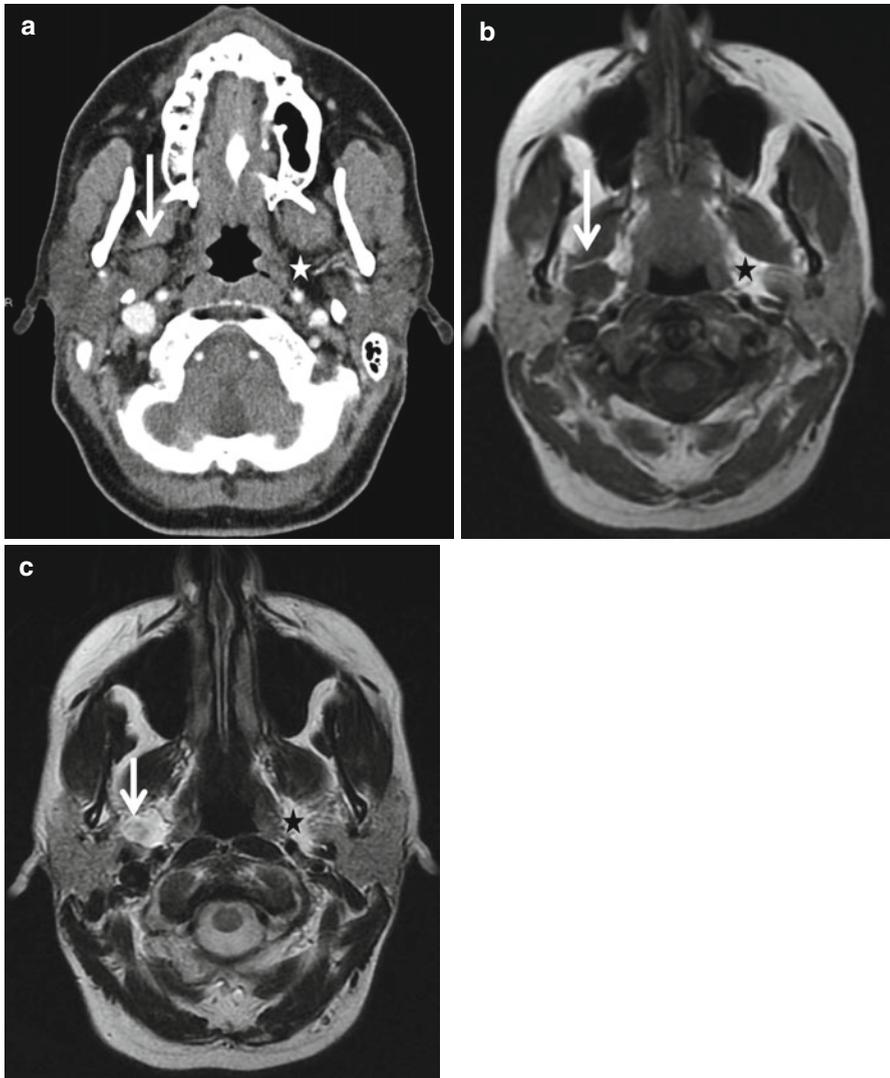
Pleomorphic adenoma. Axial CT (a) and T1- and T2-weighted MR images (b and c) display a well-circumscribed lesion centered within the right parapharyngeal space (*white arrow*). Note the thin rim of fat surrounding the lesion. The contralateral normal left parapharyngeal space demonstrates normal fat (*star*). Fat appears hypodense on CT (with negative Hounsfield Units) and is hyperintense on both T1 and T2 sequences. Pleomorphic adenomas usually appear hyperintense on T2-weighted sequences, as seen on image (c)
